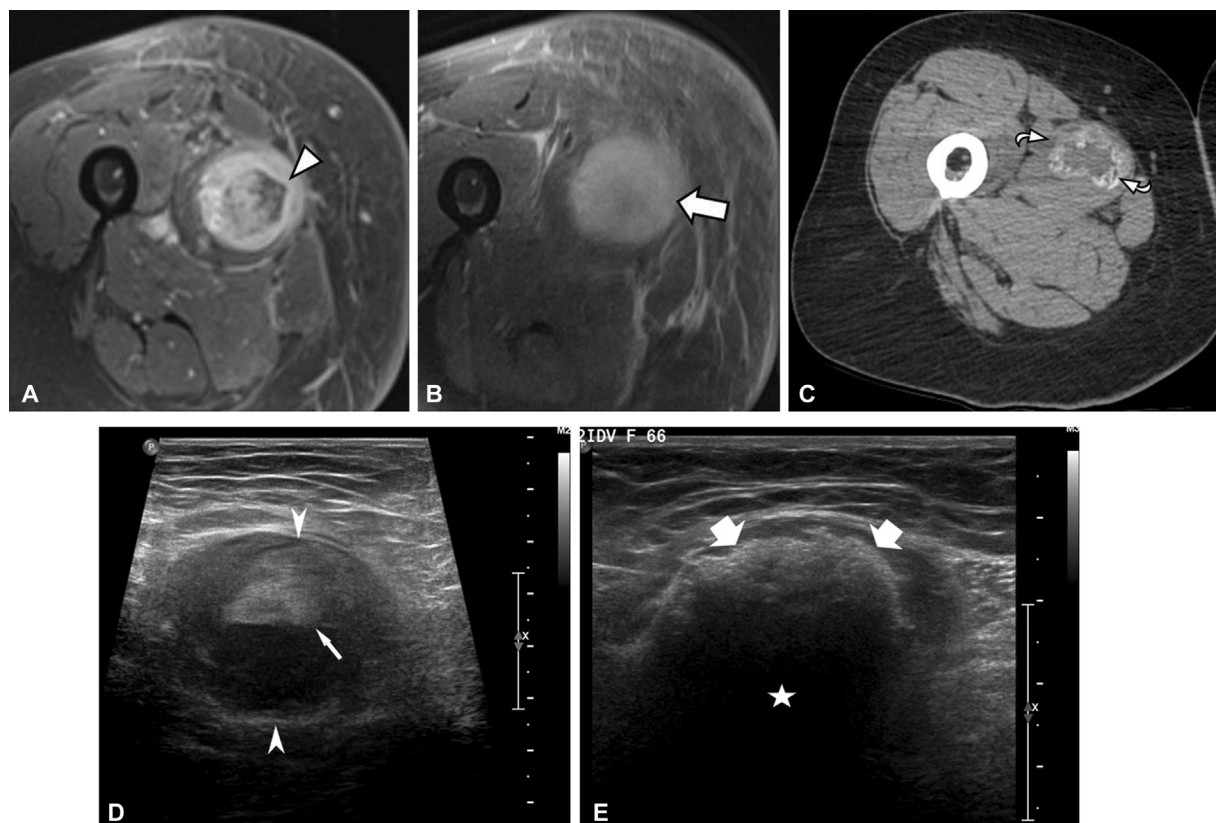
A 45-year-old man with palpable medial thigh mass and remote history of trauma. The mass (*arrowhead*) has heterogeneous high signal on the (A) axial T2-weighted fat-suppressed magnetic resonance (MR) image and solid enhancement (*arrow*) on the (B) axial T1-weighted fat-suppressed postcontrast MR image. (C) Axial noncontrast computed tomography (CT) image in soft tissue window shows an intramuscular peripherally calcified lesion (*curved arrows*) in the adductor longus muscle with zonal ossification pattern consistent with myositis ossificans. Ultrasound image at presentation (D) shows a heterogeneous mass (*pointed arrows*) with a fluid level (*thin arrow*). Three months later, (E) the mass has peripheral calcification (*block arrows*) with posterior shadowing (*star*).
